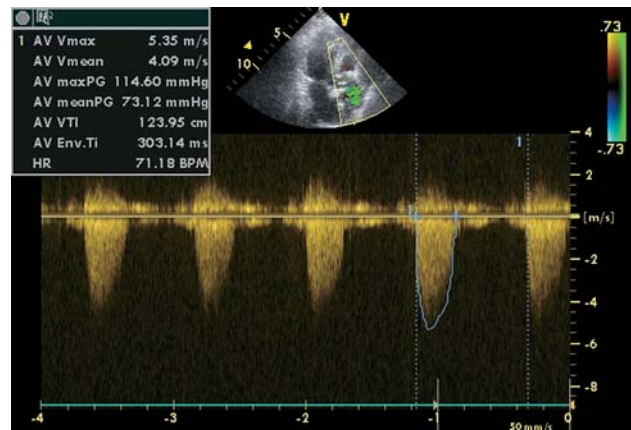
Patient V., 75 years old, transthoracic echocardiography (prior to TAVI). Continuous wave Doppler study, apical approach. Aortic valve (AV) systolic pressure gradient measurement. Peak gradient between the left ventricle and aorta is 114 mmHg, mean – 73 mmHg.
